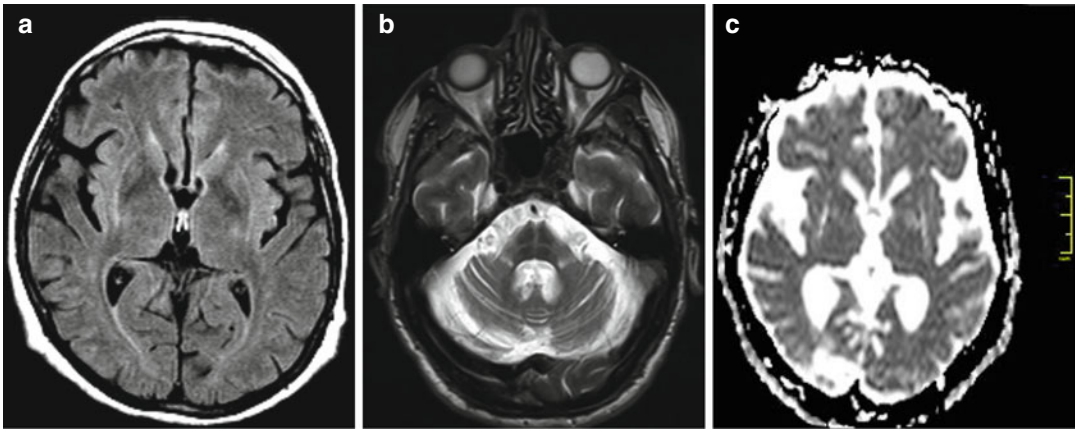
(a) FLAIR image acquired at 1.5 tesla. Axial plane at the basal ganglia level in a MSA-P patient. A hyperintense rim surrounding the lateral margins of the putamen can be seen bilaterally, more prominent posteriorly on the right. (b) T2w axial plane at the MCP level in a MSA-C patient. Thinning and hyperintensity of both MCP, along with severe vermian and bilateral hemispheric
